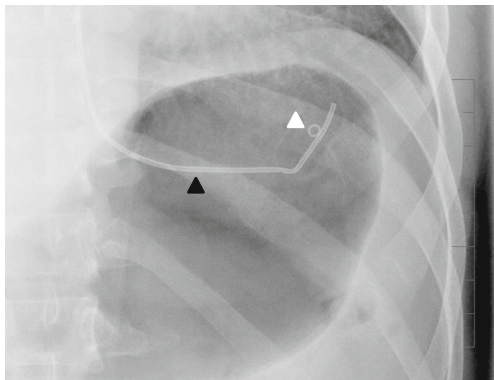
X-ray of Elipse™ after it is swallowed but before it is filled. The radiopaque catheter (*black arrowhead*) is seen entering the stomach. The radiopaque marker inside Elipse™ (*white arrowhead*) is also visible
